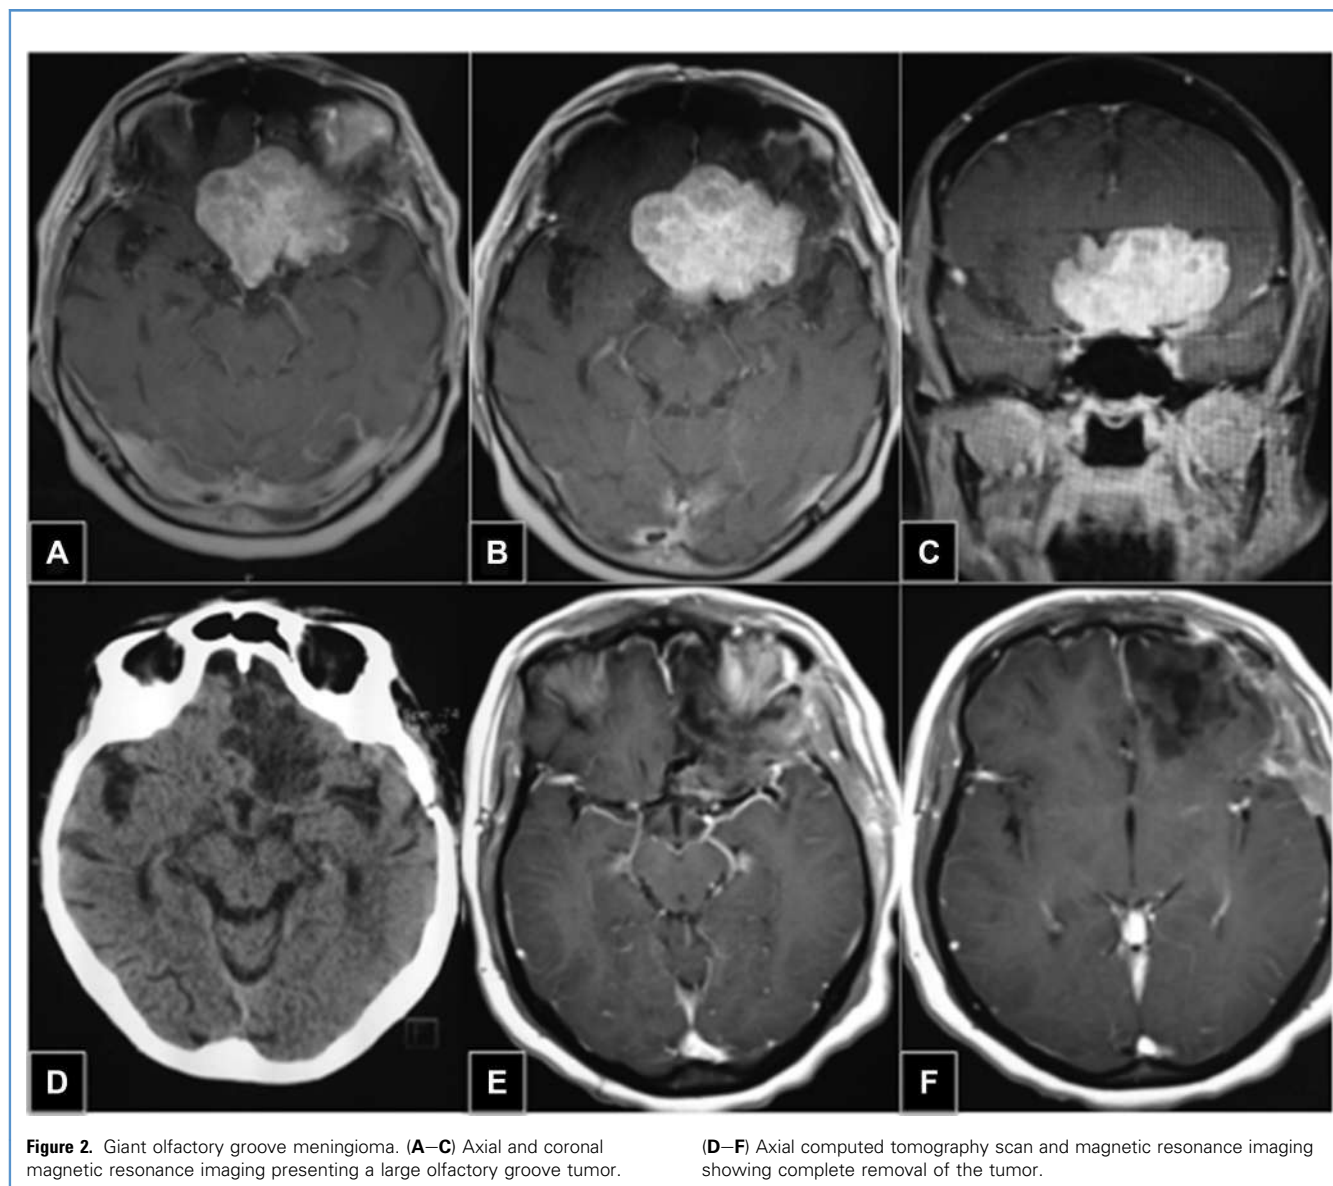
Giant olfactory groove meningioma. (A–C) Axial and coronal magnetic resonance imaging presenting a large olfactory groove tumor.
